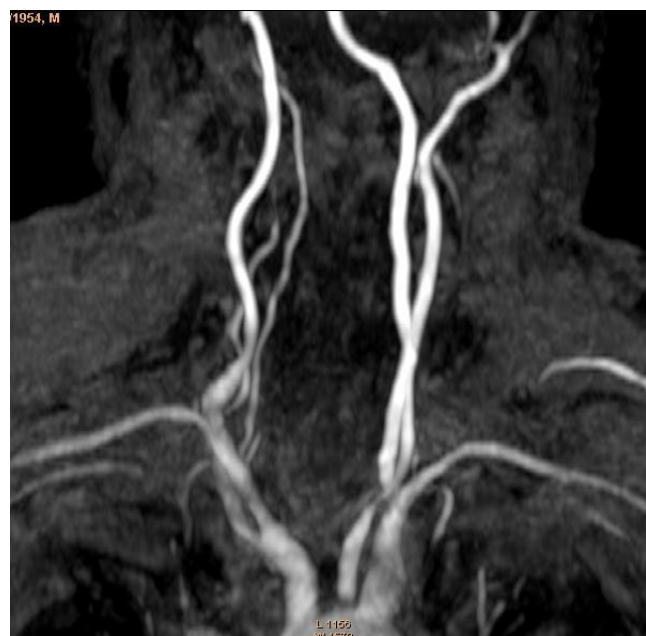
Cervical vessels MRI angiography (TOF) confirming the left ICA absence & right external carotid artery occlusion or agenesis with hypoplastic right vertebral artery along with accessory vertebral or collateral.
